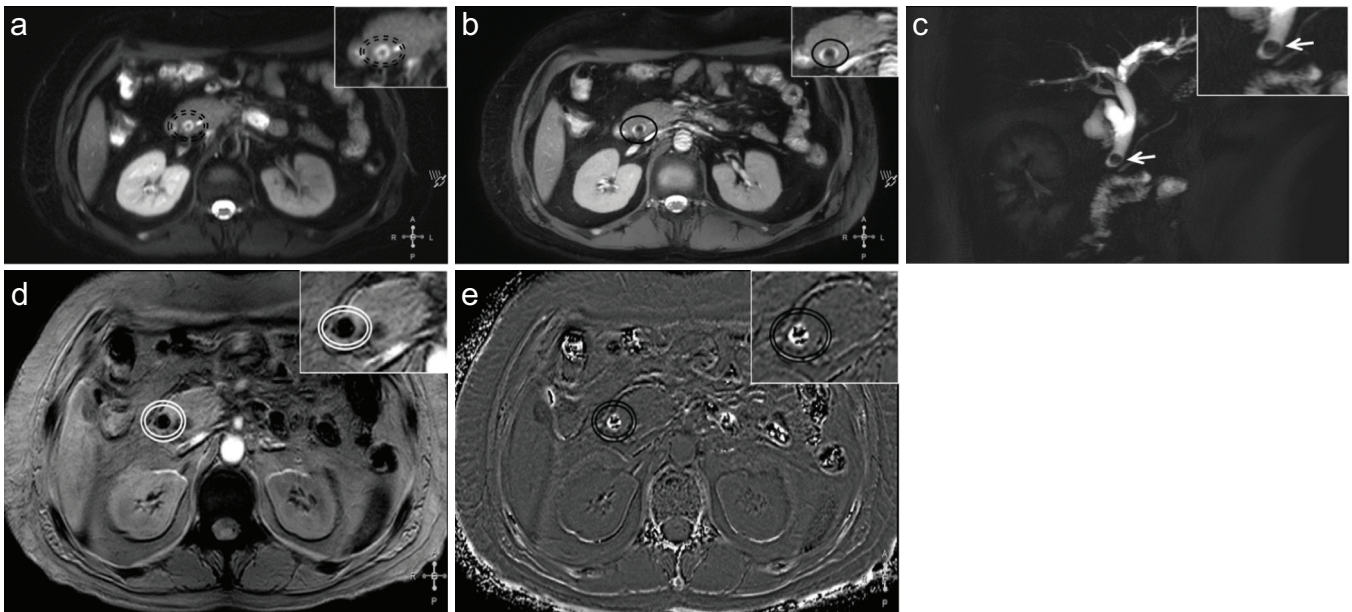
a-e. SWI was same as conventional techniques—comparative collage of images from the same anatomical level, from one of the patients where SWI data provided information same as conventional techniques in identifying CBD stone. T2-weighted (a), BTFE (b), and MRCP (c) clearly indicate the presence of a calculus in the same location. Similarly, SWI data demonstrate the calculus with hypointense signal in magnitude (d) and mixed phase signal in the phase image (e) in the corresponding region.
